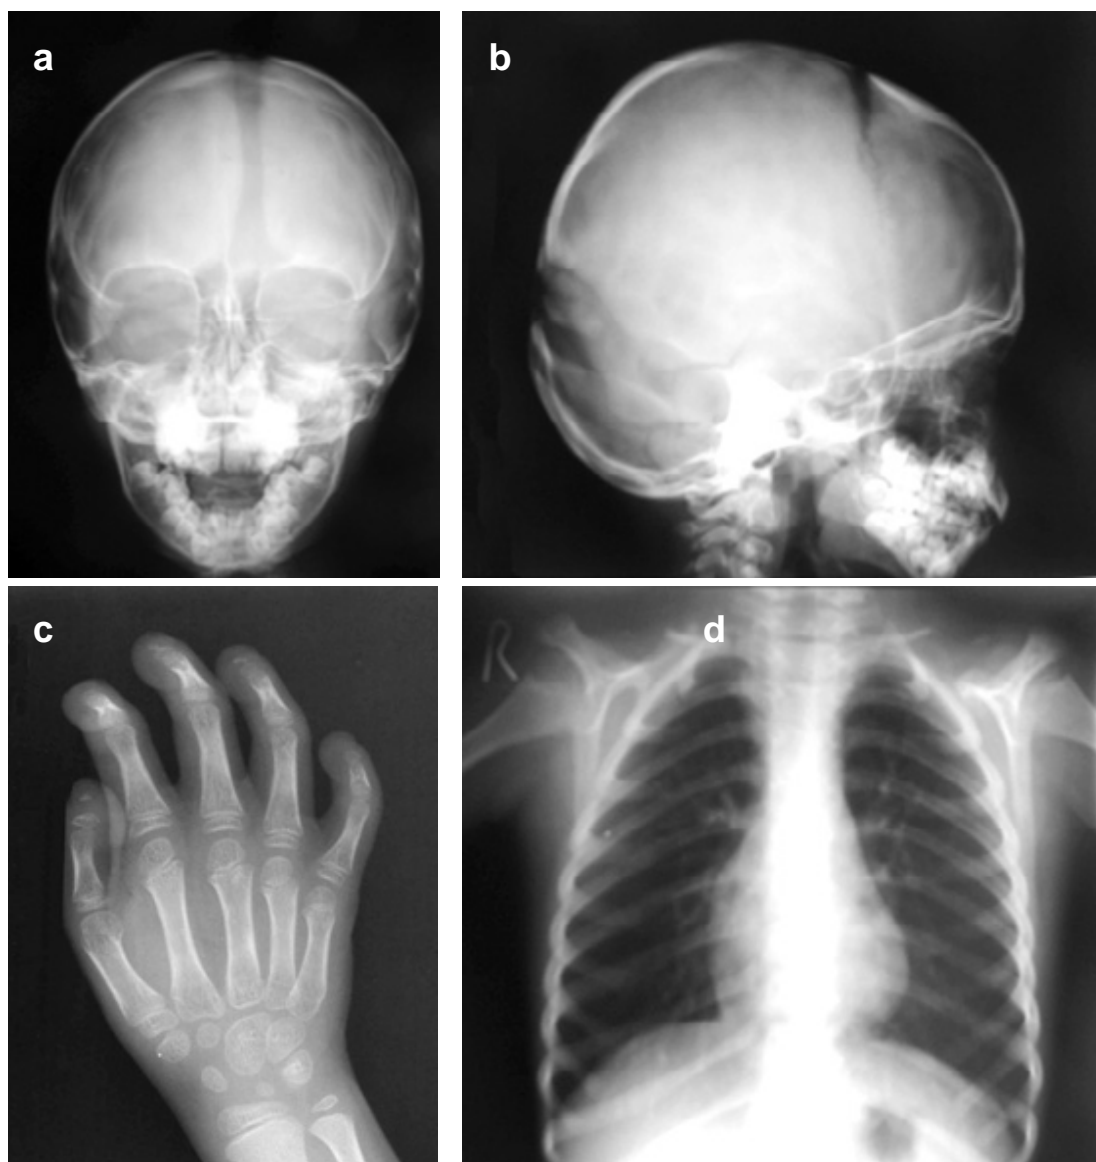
Radiography shows open cranial sutures (a), mandibular hypoplasia (b), clavicular hypoplasia (c), and osteolysis of distal phalanges (d).
